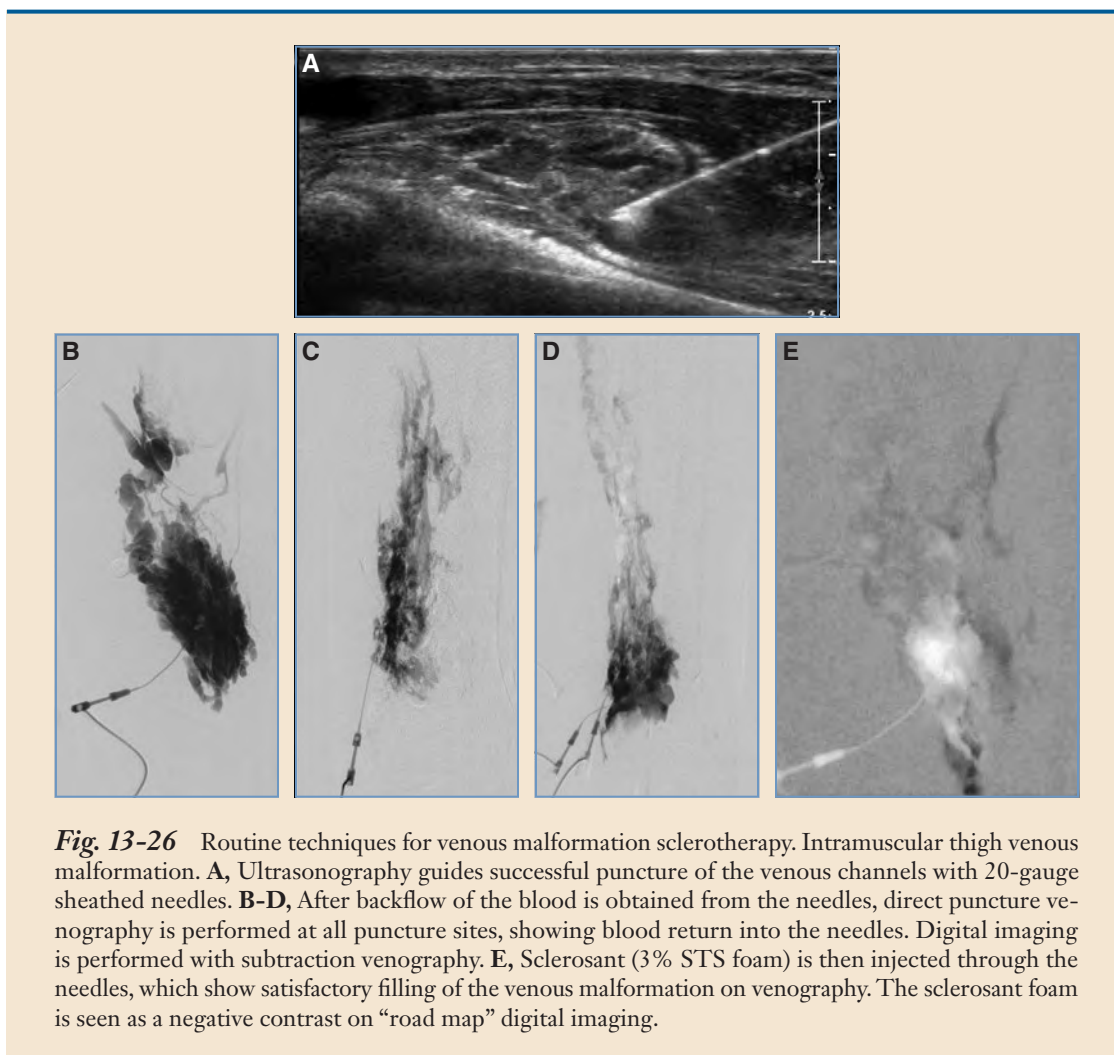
Routine techniques for venous malformation sclerotherapy. Intramuscular thigh venous malformation. A, Ultrasonography guides successful puncture of the venous channels with 20-gauge sheathed needles. B-D, After backflow of the blood is obtained from the needles, direct puncture venography is performed at all puncture sites, showing blood return into the needles. Digital imaging is performed with subtraction venography. E, Sclerosant (3% STS foam) is then injected through the needles, which show satisfactory filling of the venous malformation on venography. The sclerosant foam is seen as a negative contrast on “road map” digital imaging.
